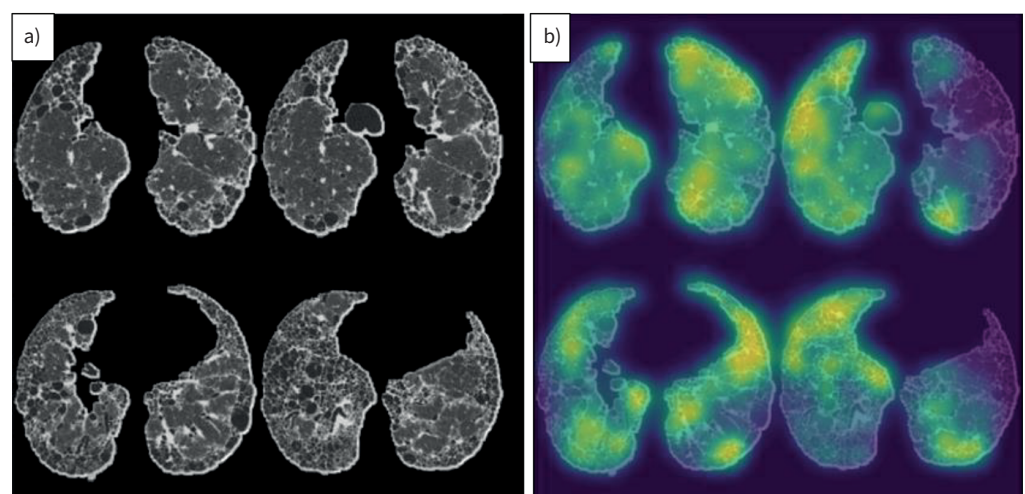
Systematic Objective Fibrotic Lung Disease Analysis Algorithm (SOFIA). a) Four-slice high-resolution computed tomography montage of segmented lung slices depicting peripheral honeycombing consistent with a usual interstitial pneumonia (UIP) pattern. SOFIA scores for this case were UIP 0.9963; probable UIP 0.0036; indeterminate 0.0001; and alternative diagnosis 0.000. b) Saliency map for a), highlighting regions within the montage that were the most influential in algorithmic decision-making.
